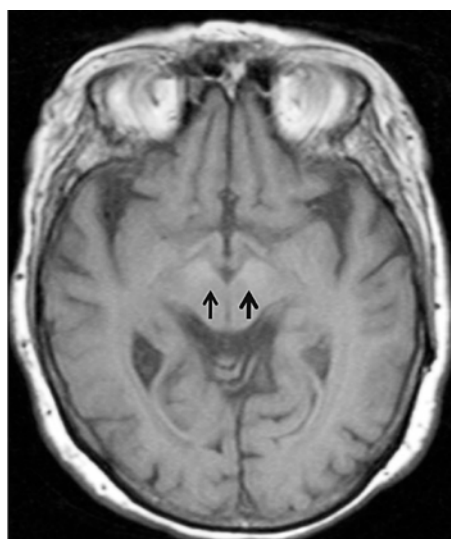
Magnetic resonance imaging of the brain, axial section, T1-weighted data. Image of hyperintense areas in the cerebral peduncles (arrows).
